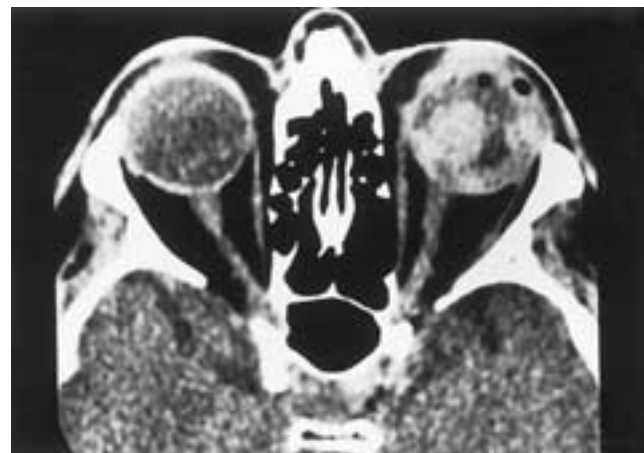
Choroidal hematoma following ocular surgery. Axial CT scan shows multiple choroidal hematomas of various sizes involving the left eye.
